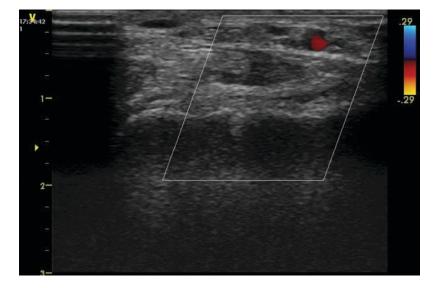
Flow highlighted by Doppler colour in the radial artery. Linear probe 12 mhz
